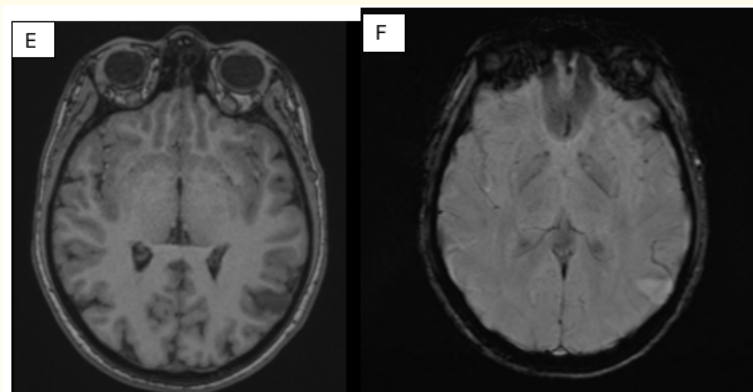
Figure A-F: A: Axial T2-weighted MRI showing a well-circumscribed hyperintense cystic lesion in the left parietal lobe. B: Axial FLAIR MRI demonstrating partial suppression of the lesion signal. C: Coronal FLAIR MRI showing smooth cyst margins and absence of perilesional edema. D: Sagittal T1-weighted MRI revealing a hypointense cystic lesion with mild cortical compression. E: Axial T1-weighted MRI after gadolinium injection showing no enhancement. F: Axial SWI sequence excluding calcifications or hemorrhage.
